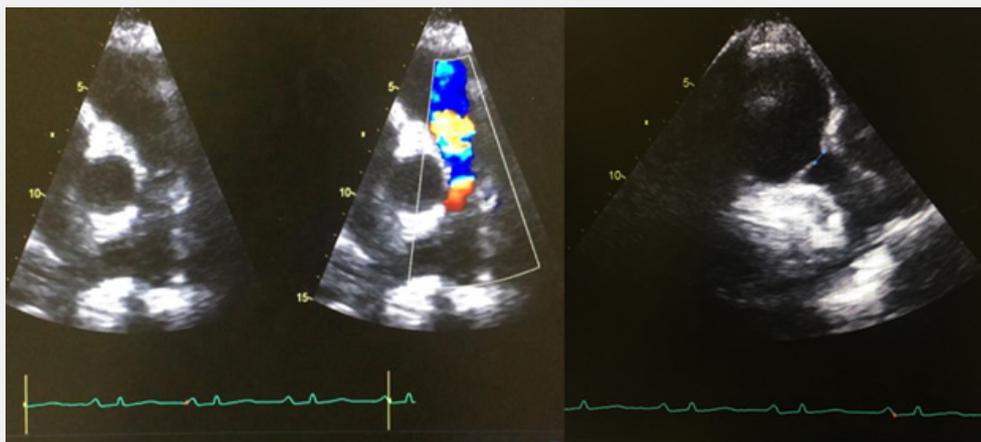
Parasternal short axis view showing thickened and retracted pulmonary valve with severe regurgitation and coaptation gap.
